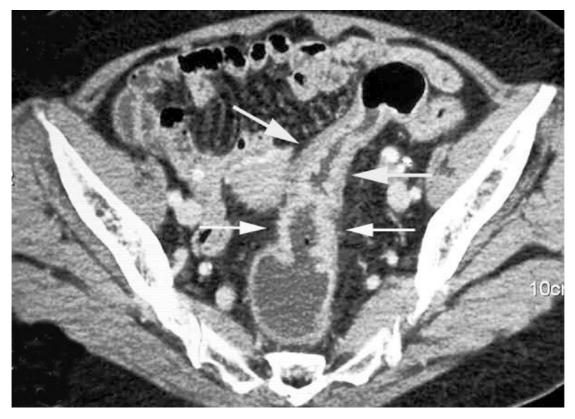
CT scan is correctly staged for sigmoid tumor confined to colonic wall (arrows)
